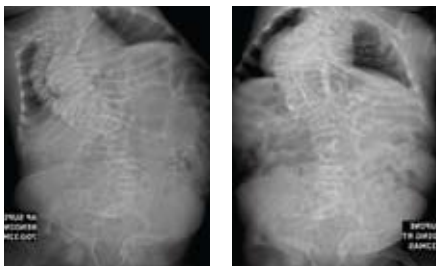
Pre-op radiography.
